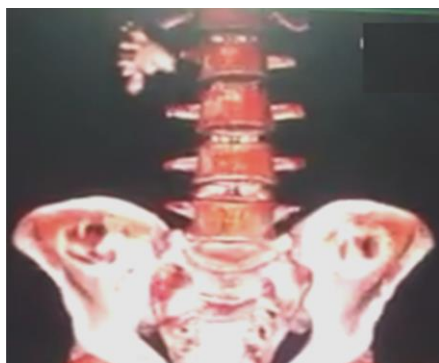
Noncontrast CT with coronal reconstruction showing complete staghorn stone in the right kidney
